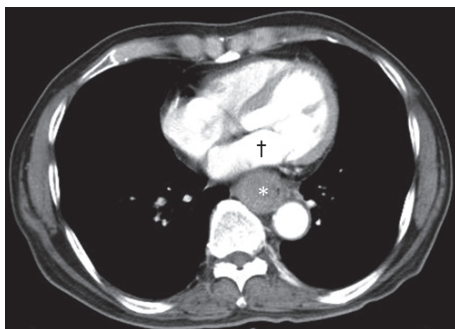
Chest CT reveals an esophageal mass (*) which compresses the left atrium (†).
